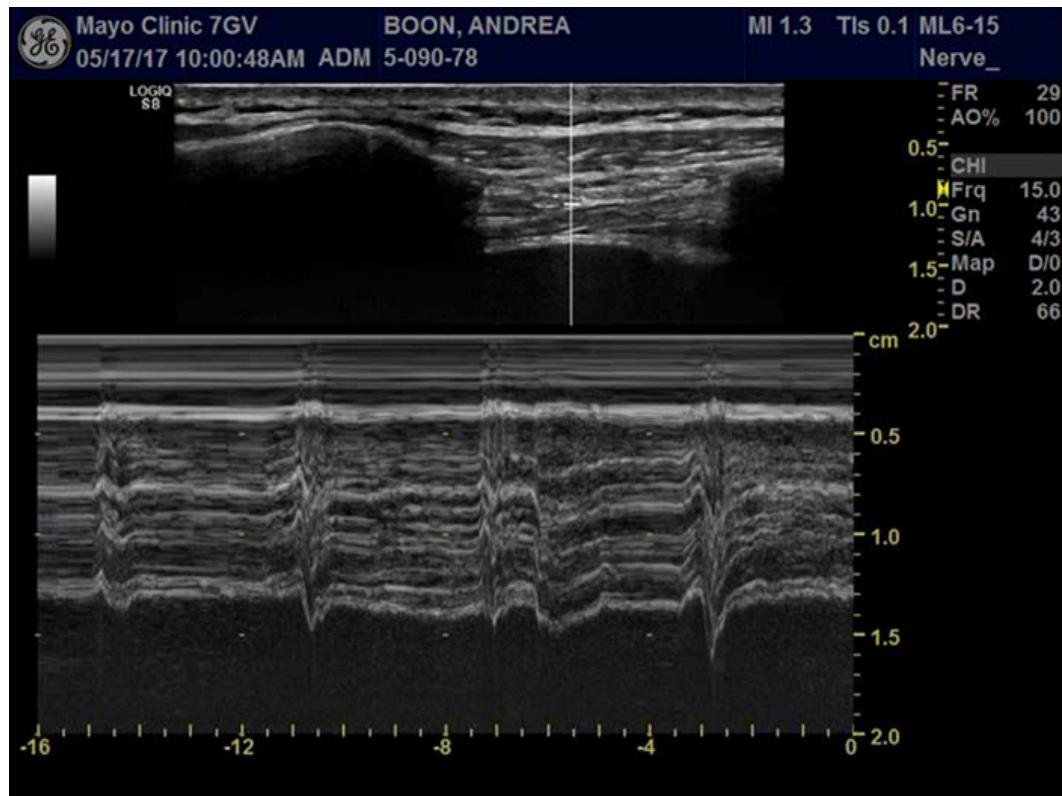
Sniff test: an ultrasound-guided ABCDE approach.
